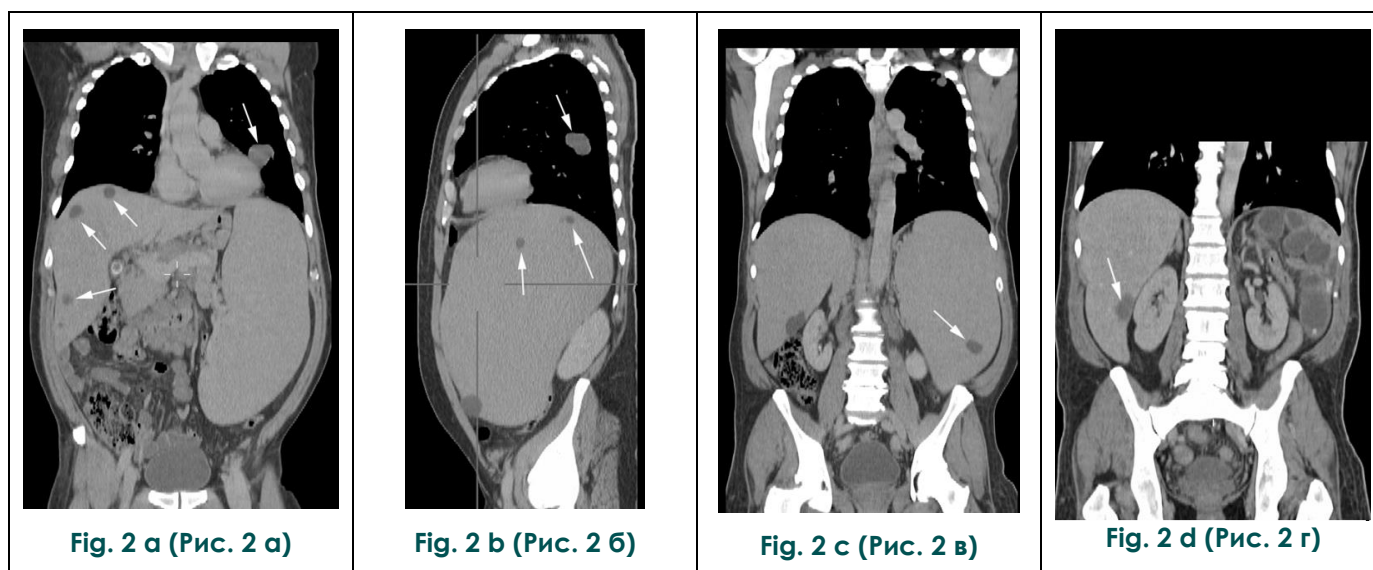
CT, abdomen, multiplanar reconstructions. A-D – multiplanar reconstruction confirmed the hepatomegaly and splenomegaly with evidence of 5 cystic lesions in the right liver lobe and at least four cystic lesions in the upper and lower poles of the spleen (white arrows).
